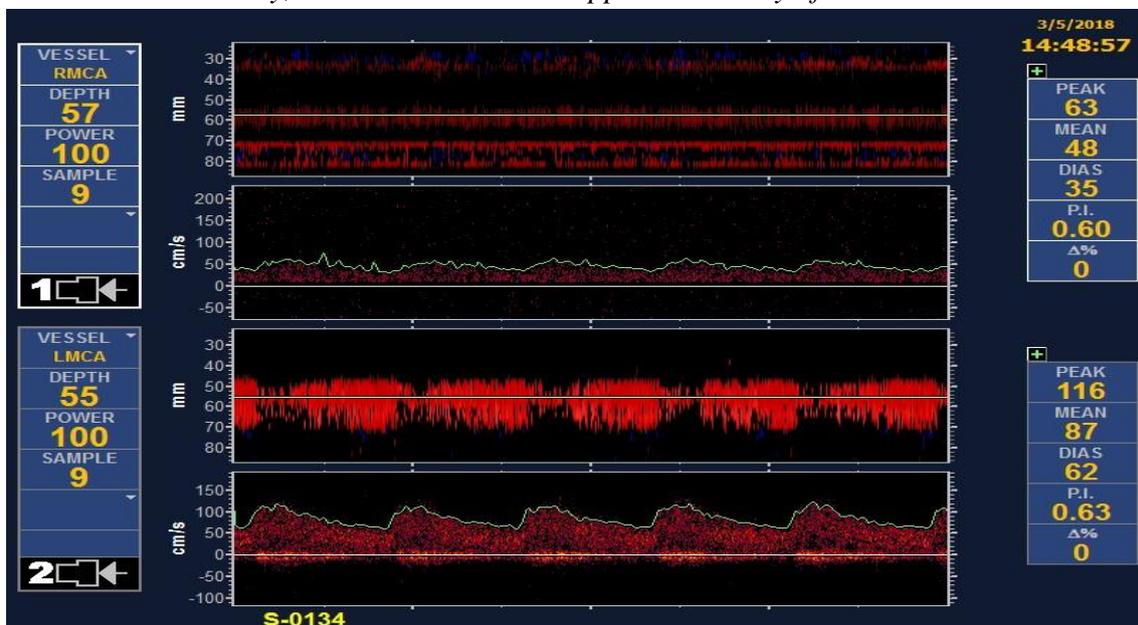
TCD showing decreased flow in the right MCA upon clamping during CEA. CEA: carotid endarterectomy, DIAS: end-diastolic velocity, MEAN: mean flow velocity, PEAK: peak systolic velocity, P.I.: pulsatility index, RMCA: right middle cerebral artery, TCD: transcranial Doppler. Courtesy of Dr. Zsolt Garami.
